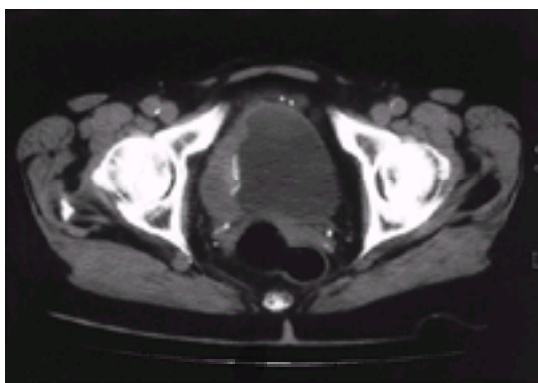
Computed tomogram showing an invasive tumour in the right side of the bladder.
